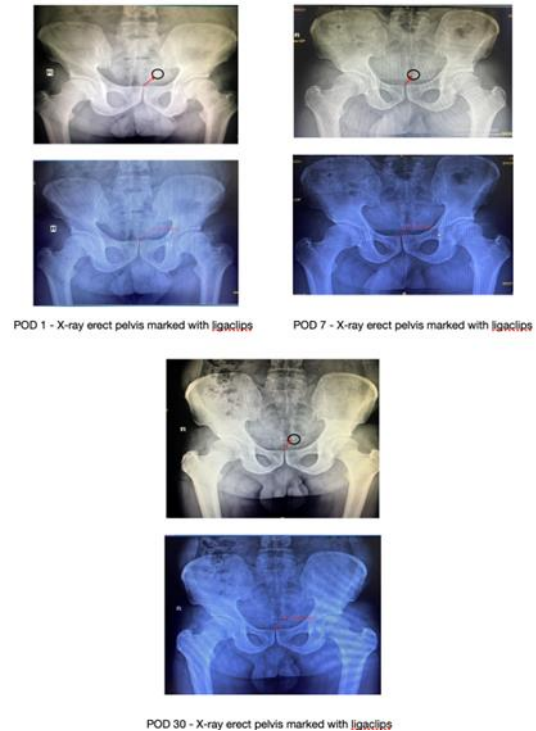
Post-operative serial X-rays on POD 1, POD 7, and POD 30
